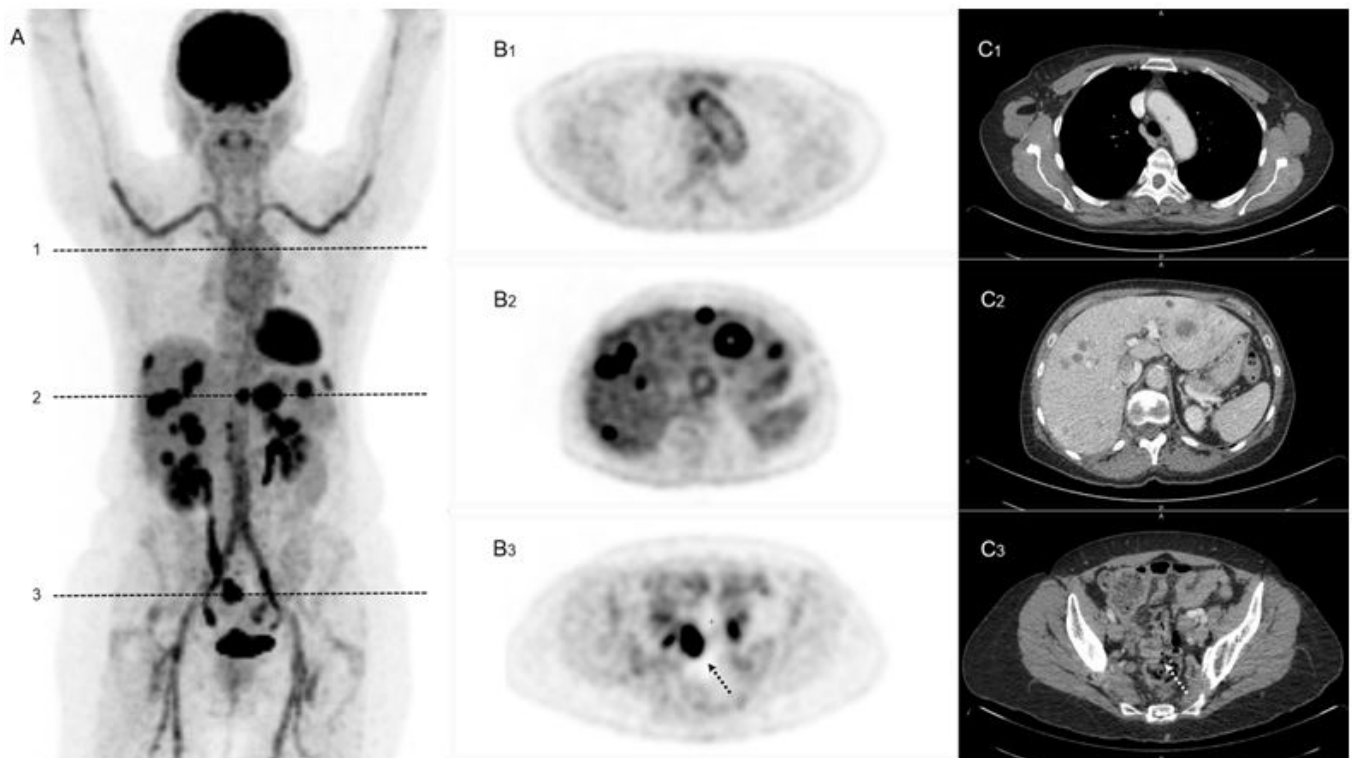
The maximal intensity projection image (A), the PET (B) and enhanced CT (C) slices show hypermetabolic thickening of large vessels' wall (B₁ and C₁), liver metastases (B₂ and C₂) and the tumor (dotted arrows on B₃ and C₃).
